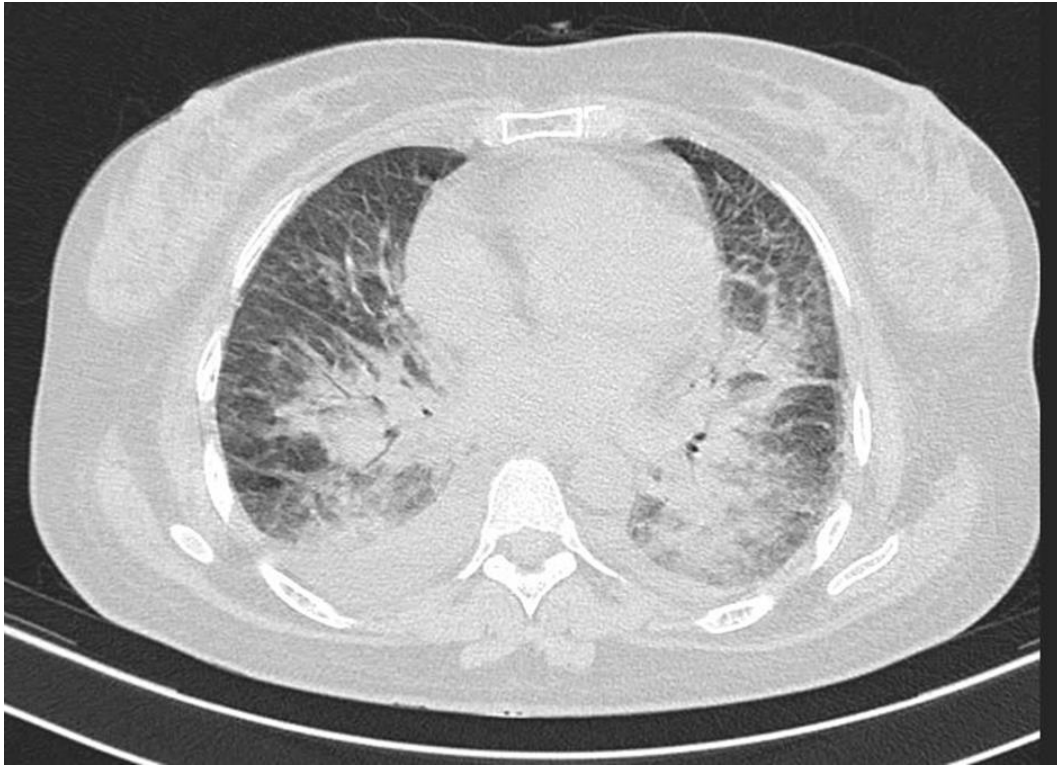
Axial section of HRCT Thorax showing bilateral central peri-bronchovascular Ground glass Opacities (GGO) predominantly in lower lobes with bilateral pleural effusion.
